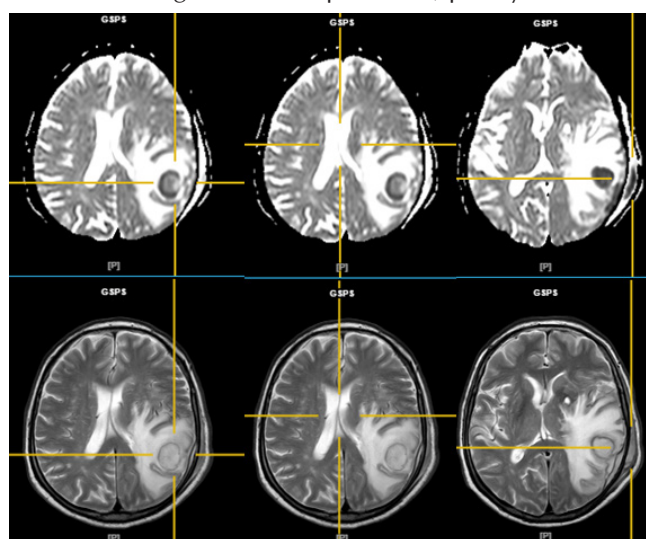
MRI Imagery Shows Multiple Ring Enhanced Lesion And Perifocal Edema On The Sinistral Parieto-temporal Lobe, Mass Effect Caused By Perifocal Edema Causing Midline Shift, Obliteration Of Left Lateral Ventricle And The Dilation Of The Right Ventricle, Subcuticular Empyema.
